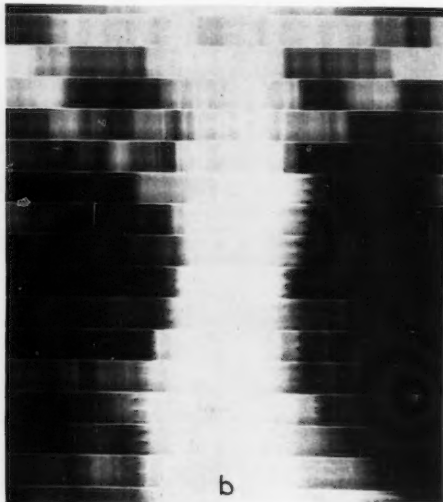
Normal appearance of aortic knob and left upper mediastinum in roentgenogram (a) and roentgenkymogram (b). The patient was a woman 30 years of age. There was absence of pulsations on the left above the aortic knob.
